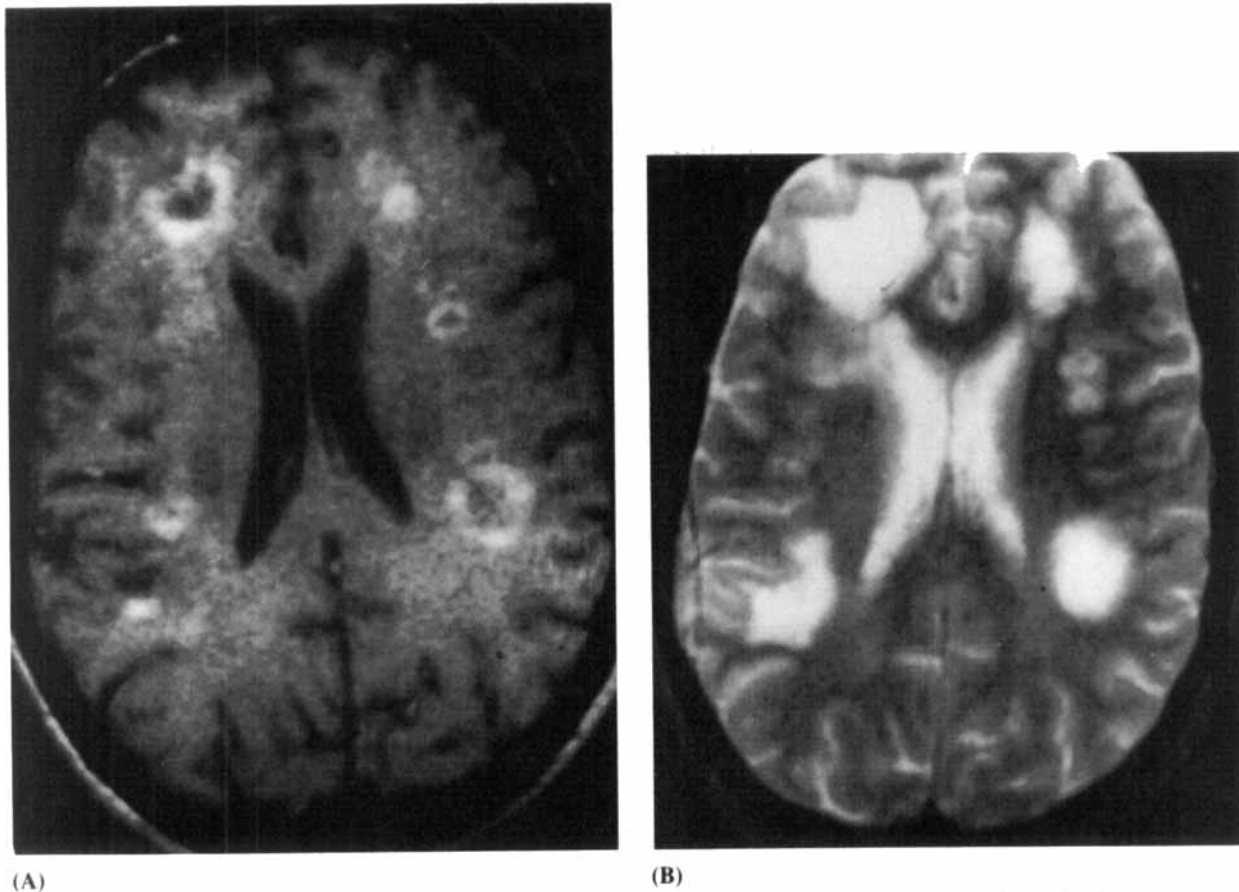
(A) Axial projection of a T1-weighted magnetic resonance image demonstrating multiple ring-enhancing white matter lesions. (B) Axial projection of a T2-weighted image demonstrating multifocal high-intensity lesions.
